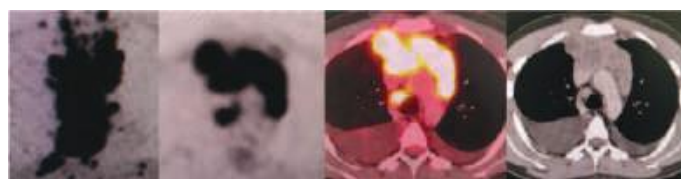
PET CT in Mediastinal B-Cell Lymphoma – PET scan reveals metabolically active mediastinal mass lesions and CT scan localizes them to be mediastinal L-node masses
